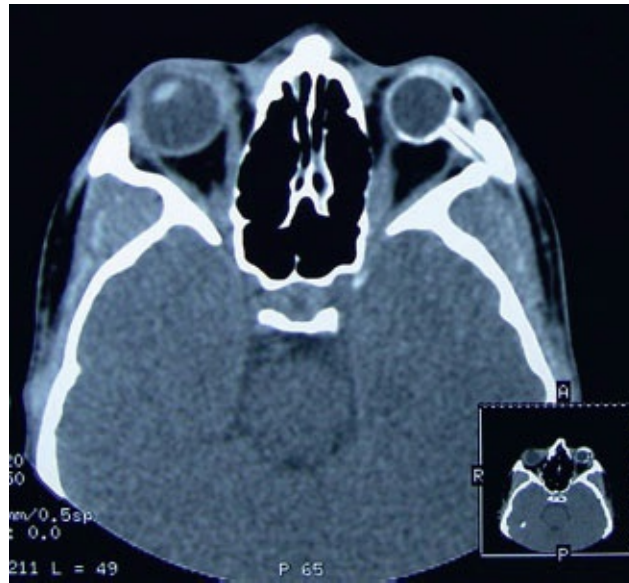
• Follow-up CT scan showing the appropriate position of the intraorbital tissue expander.
